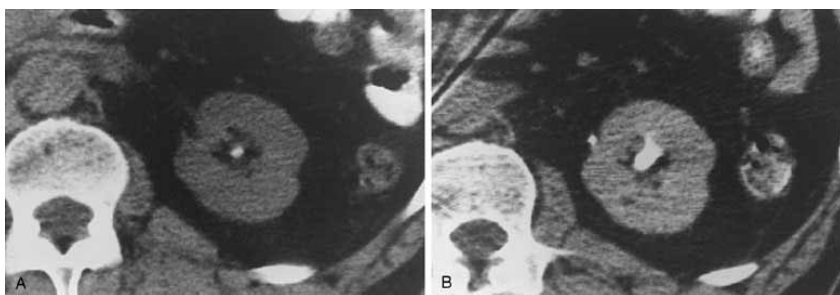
CT scan, view the stone in the kidney medulla
